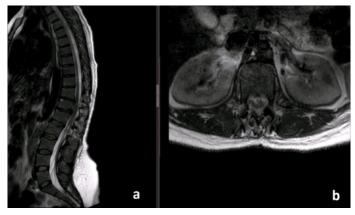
L1-L2 epidermoid lesion total excised. Postoperative thoracolumbar T2 sagittal (a) and axial (b) section MRI
